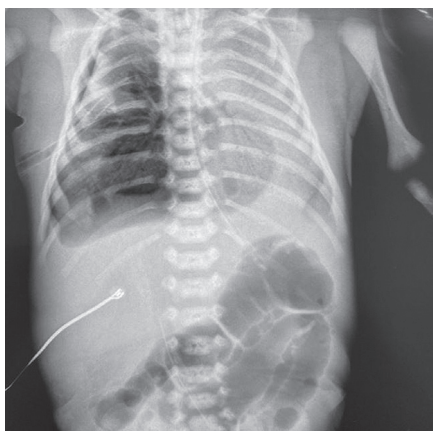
Chest X-ray of newborn after monobronchial surfactant administration
